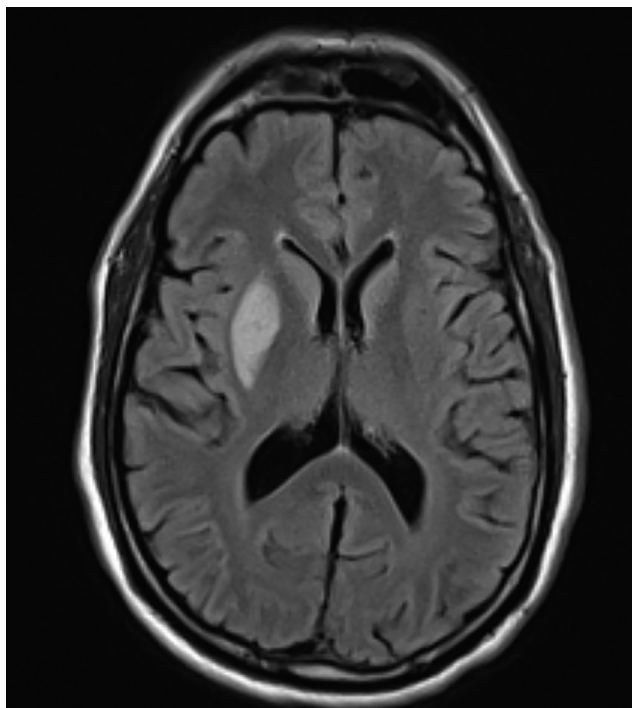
MRI Brain showed foci of acute ischemia in the right caudate nucleus and right basal ganglia.
